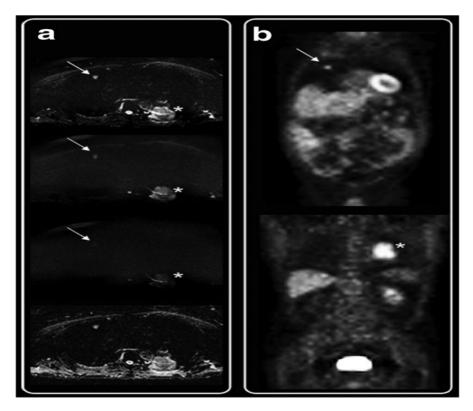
DWI and PET images of a male patient with multifocal bronchial carcinoma; the original b-value images with b-values of 0,400, and 1,000 s/mm² and ADC-map are given from the bottomup in (a) and the coronal PET with ¹⁸F-FDG are given in (b). Both methods highly sensitively depict the small tumor in the lung (shown with permission of Lippincott Williams and Wilkins; taken from Lichy et al., Invest Radiol 2007; 42: 605–613)
